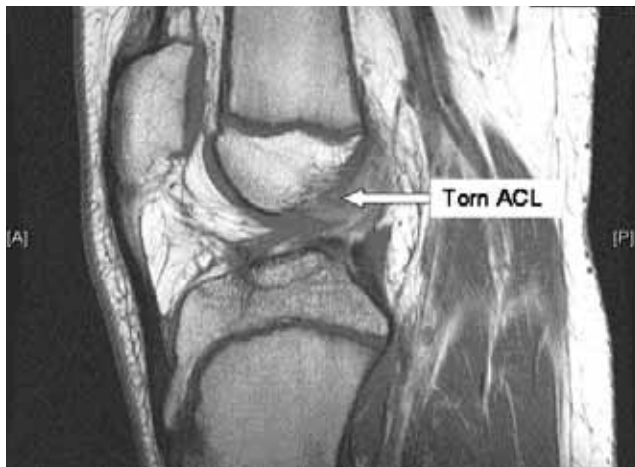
Sagittal magnetic resonance imaging shows anterior cruciate ligament tear in patient with open physes.
